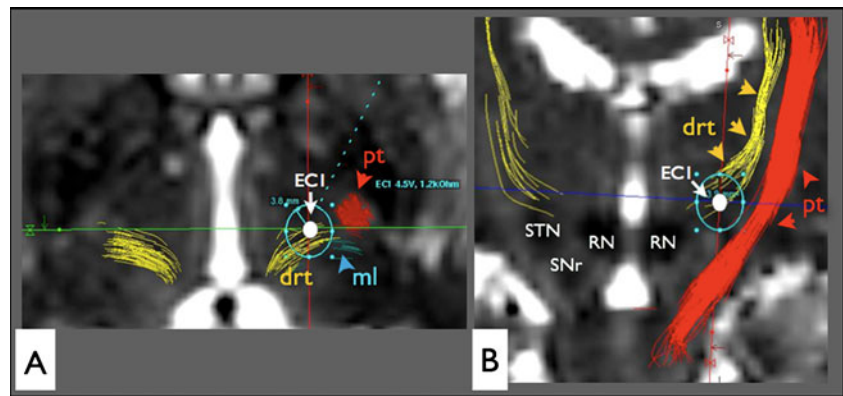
Individual fiber map of the thalamic (A–C) and subthalamic (D–E) regions in axial T2-weighted high-resolution display. A, B Effective electrode contact positions (EC9, EC1) in our patient, with clear contact to the anterior part of the drt. C Traditional target level (z=0) for thalamic DBS. Note how these three target regions (Vim, pSTN, cZI; yellow) are interconnected by the drt at the thalamic/subthalamic level.
